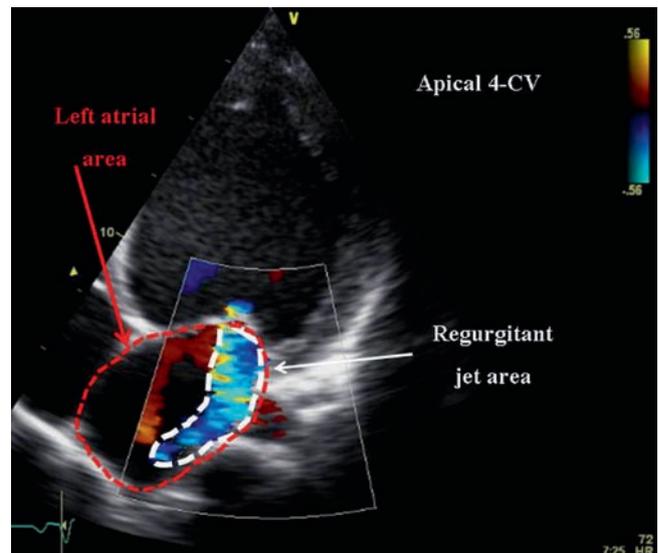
Semi-quantitative assessment of MR severity using colour flow mapping of the regurgitant jet. The ratio of regurgitant jet to left atrial area can be calculated. AP 4-CV; apical 4-chamber view
